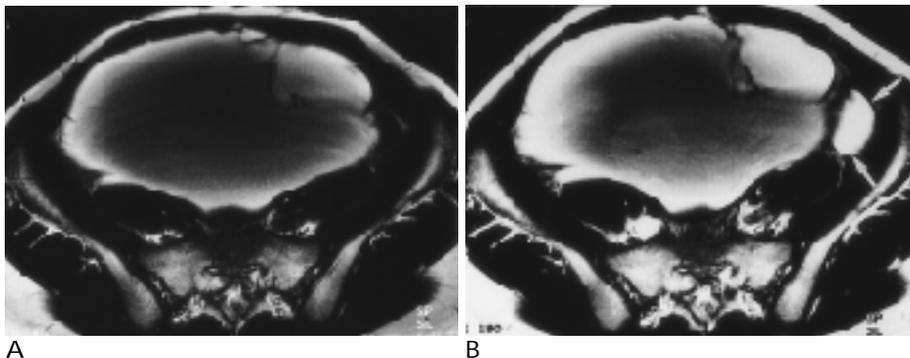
Mucinous cystadenocarcinoma in a 42-year-old woman. TSE T2-weighted axial image without Magnevist Enteral (A) shows a multi loculated cystic mass with various signal intensity of the chambers. TSE T2-weighted axial image with Magnevist Enteral (B), Enteral-filled bowel loop (arrows) mimic locule of mass.
